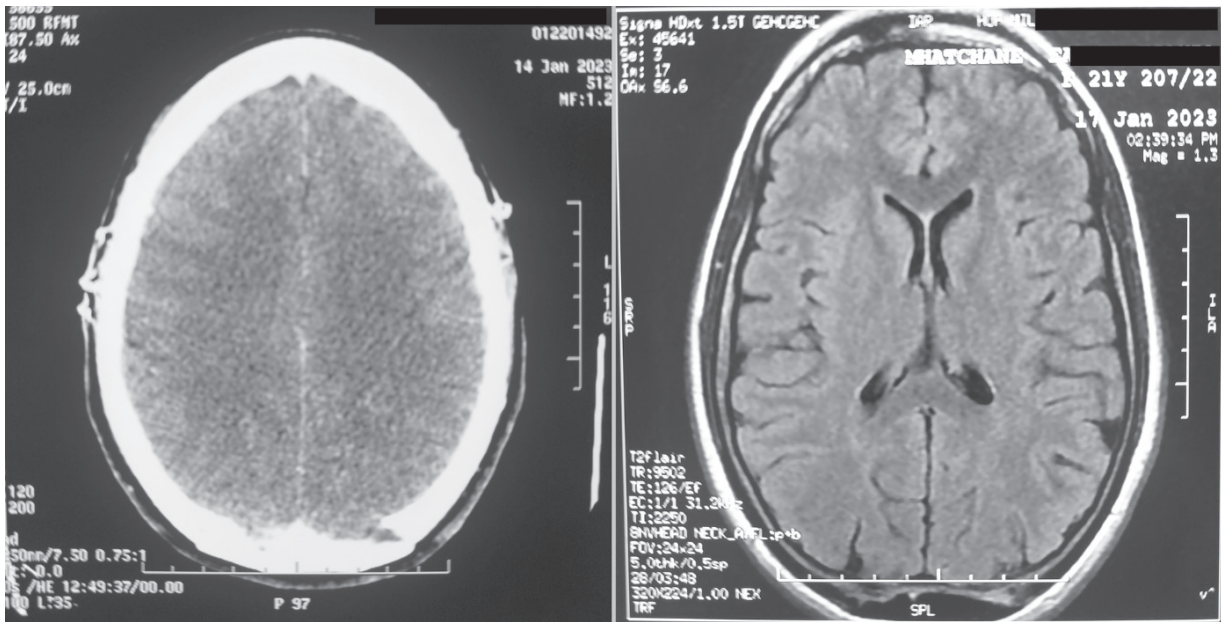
Computed tomography and magnetic resonance imaging: inflammatory changes at the cranioplasty site, no intracranial lesions or cerebral thrombophlebitis
